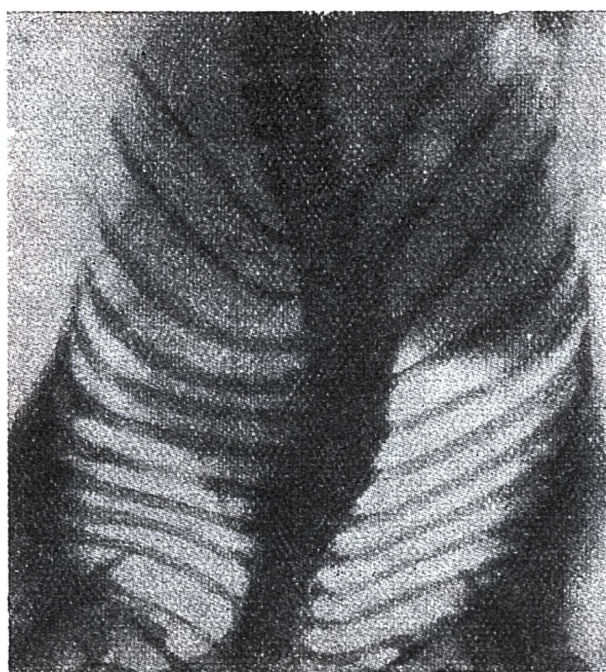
X-RAY VIEW OF A CROOKED SPINE CAUSED BY BAD POSTURE.
